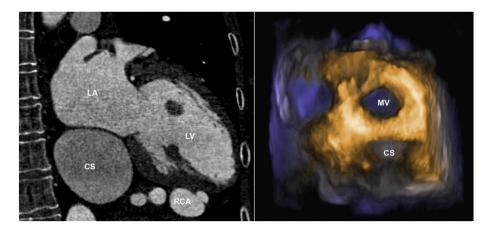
Anatomic relationship between dilated coronary sinus (CS) and heart chambers depicted by multi detector computed tomography scanner (left) and 3D transthoracic echocardiography (right). LA: left atrium, CS: coronary sinus, RCA: right coronary artery, MV: mitral valve, LV: left ventricle.
